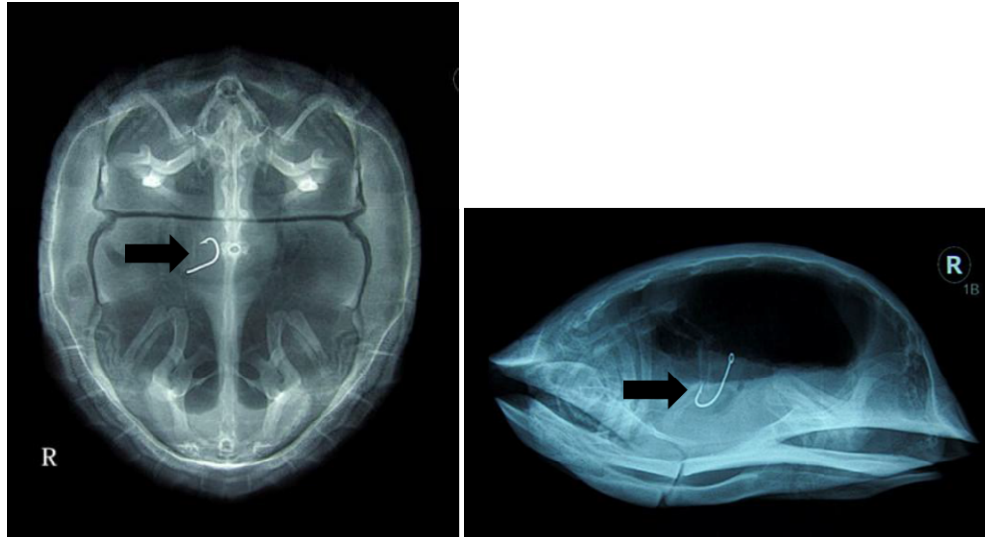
Both lateral (right) and ventral dorsal (left) views of radiograph revealed solid radiopaque foreign body in the coelomic cavity.
